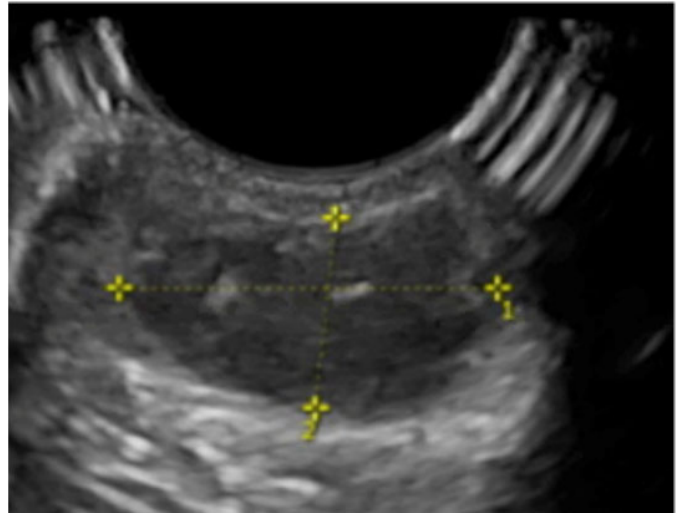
Ultrasound image of a solid-appearing vulvar mass measuring 2 × 2 cm.
